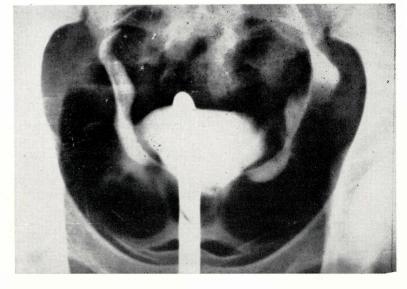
X-radiograph of bladder area, showing calcification of bladder wall.
